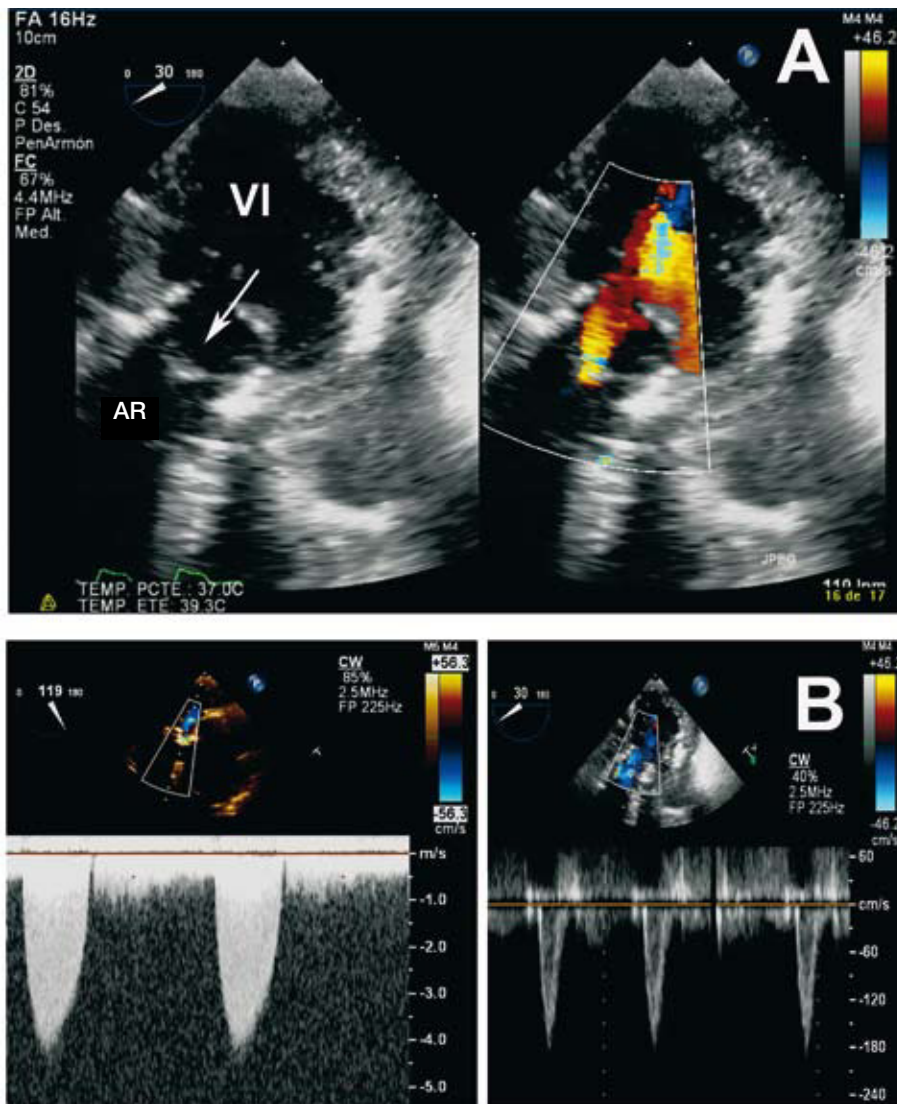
Aortic valve hemodynamic assessment before and after transthoracic implantation of the aortic valve prosthesis. A: two dimensional deep transgastric transesophageal view (left) and color Doppler (right); the prosthesis is well positioned, the leaflets show coaptation, and there is mild central regurgitation. B: spectral Doppler data obtained continuously during intraoperative transesophageal echocardiography before (left) and after (right) transthoracic implantation of the aortic valve prosthesis; note the normalization of the transvalvular flow velocity. AR indicates aortic root; LV, left ventricle.
